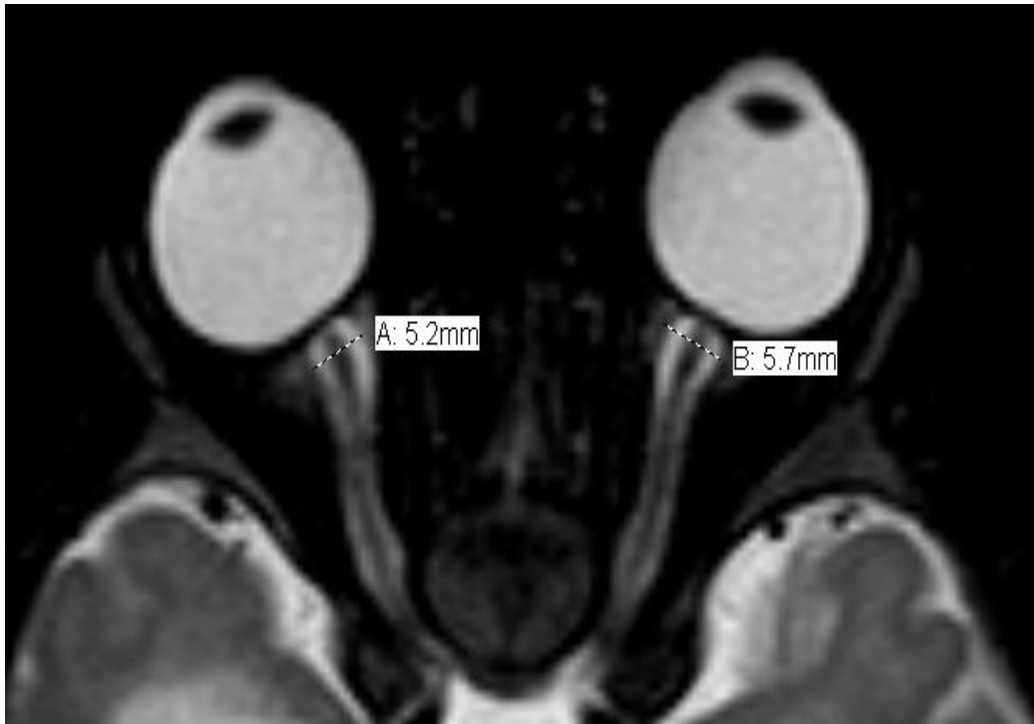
Axial T2-weighted MRI showing ONSD measurement
